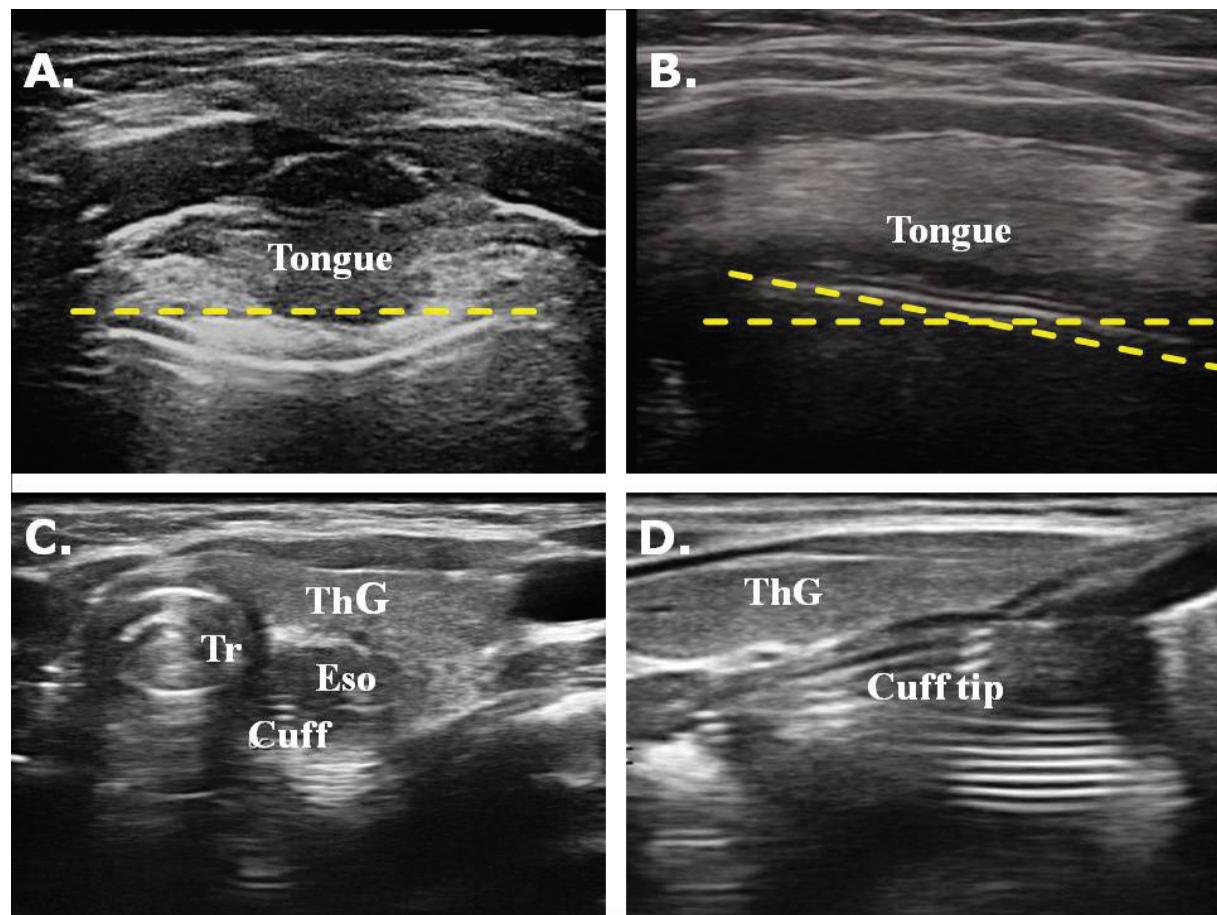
A) Symmetric and B) asymmetric sonographic views of the cuff shadow at the level of the tongue base above the hyoid bone. C) Transverse and D) longitudinal ultrasound images of esophagus after LMA placement at the anterior neck. ThG=Thyroid gland, Eso=Esophagus, Tr=Trachea
